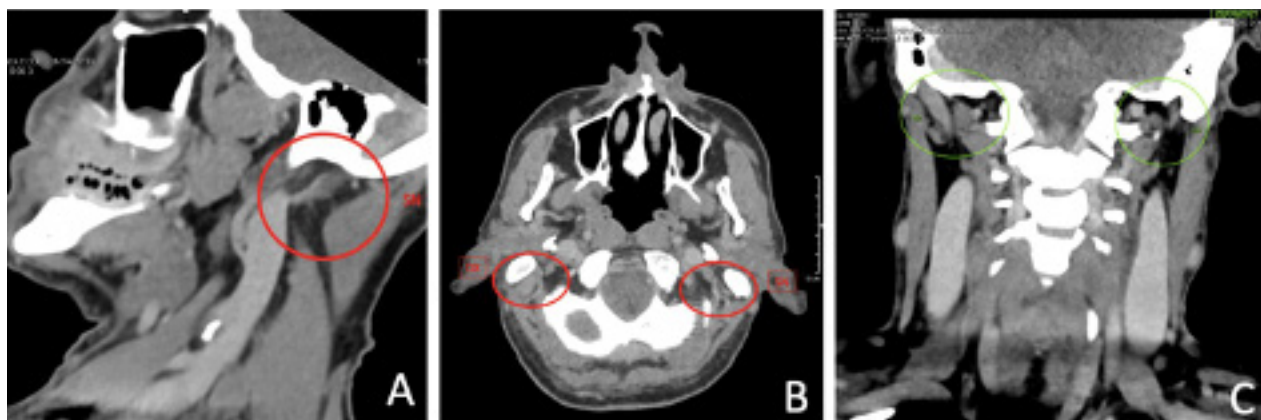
(A, B, C): CT scan imaging. In the three projections (Sagittal, Axial and Coronal projection). The anatomical defect was highlighted with a circle and compared with the contralateral side.
